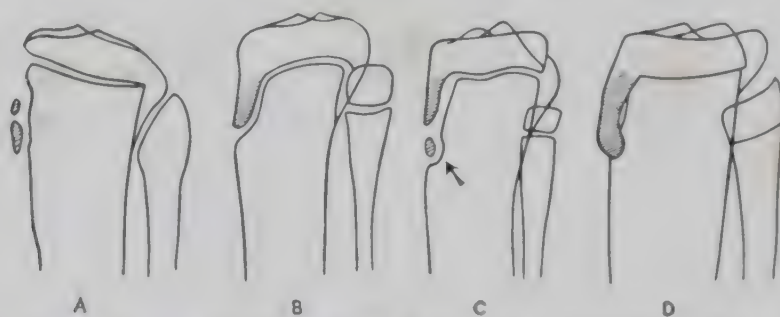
Normal variations in the size and configuration of the anterior tibial process. (Modified from Koehler. Caffey, J.: *Pediatric X-Ray Diagnosis*, Year Book Publishers, Inc.)
